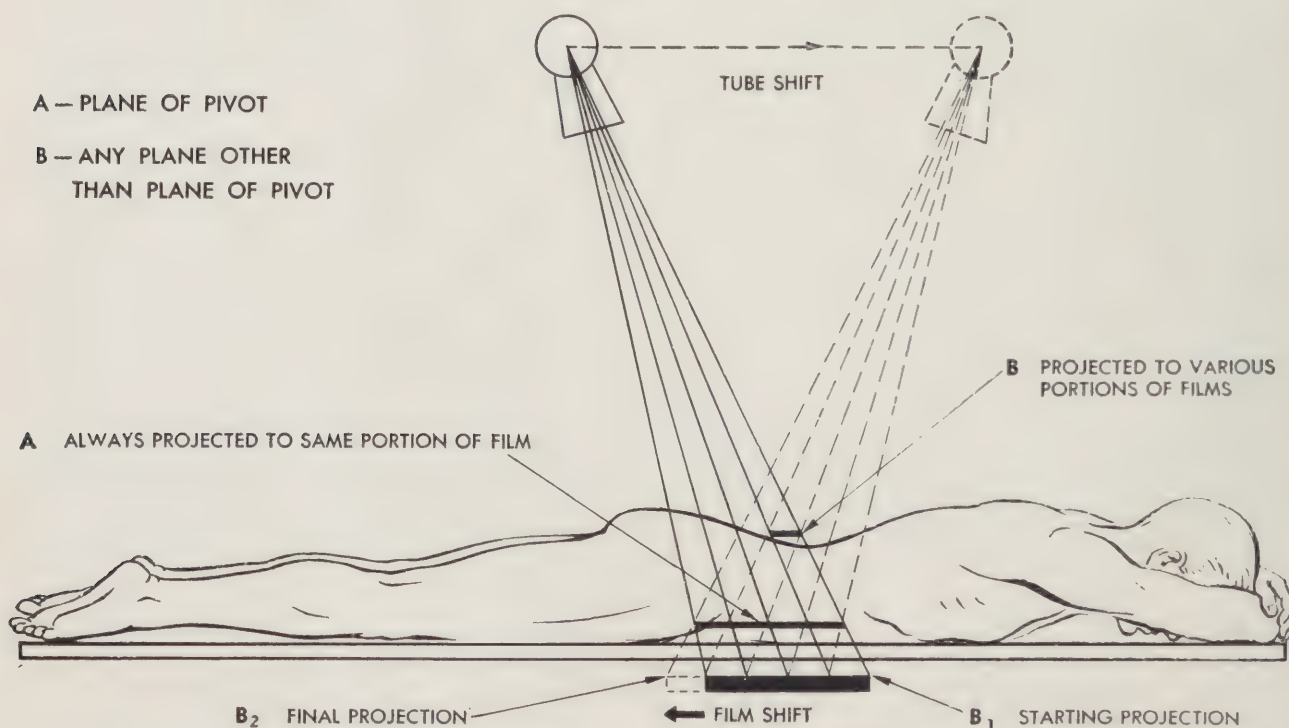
Body-section roentgenography.
